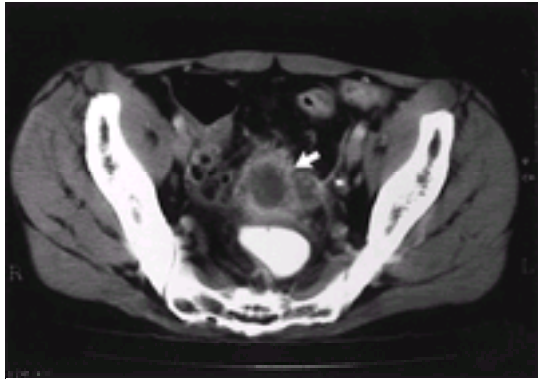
CT section of the pelvis in a patient with a diverticular abscess. Intravenous contrast medium has been given and outlines granulation tissue around the abscess cavity (arrow). This facilitates identification of inflammatory fluid collections.
